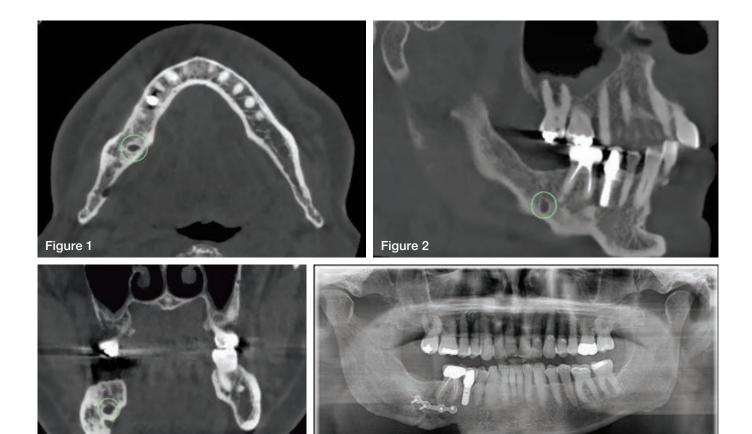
CBCT axial view showing a radiolucent lesion situated adjacent to the right lingual cortex of the mandible.
